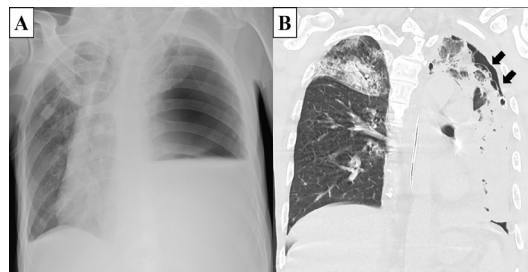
(A) Chest radiograph shows complete left lung collapse and accumulation of liquid and air in the left thorax with rightward displacement of the mediastinum and trachea. (B) CT scan revealed consolidation and subpleural cystic changes in left upper lobe (arrow point).
